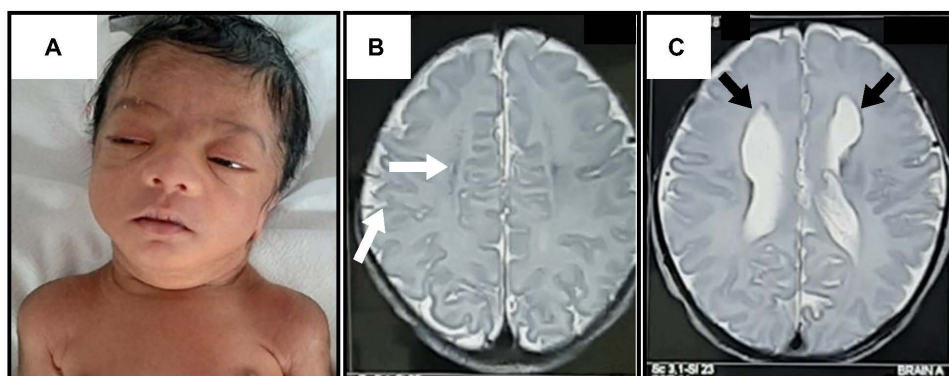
Phenotypic and clinical features of the described infant. A) Facial dysmorphisms include low-set ears, hypertelorism, periorbital edema, flattened nasal bridge, and nuchal redundancy. Head ultrasound findings include B) germinal matrix pseudocysts (white arrows) and C) bilateral ventriculomegaly (black arrows). Adapted from: A Floppy Infant with Facial Dysmorphism. Kumar P, Nerakh G, Katam P, Oleti TP, Pawar S. *Neoreviews*. 2022;23(1):e45–e48.¹
